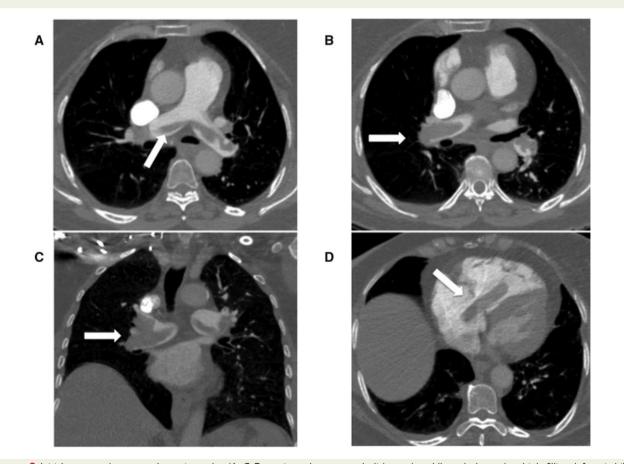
Initial computed tomography angiography. (A–C) Extensive pulmonary emboli (arrow), saddle embolus and multiple filling defects in bilateral pulmonary arteries. (*D*) Clot in transit (arrow).
